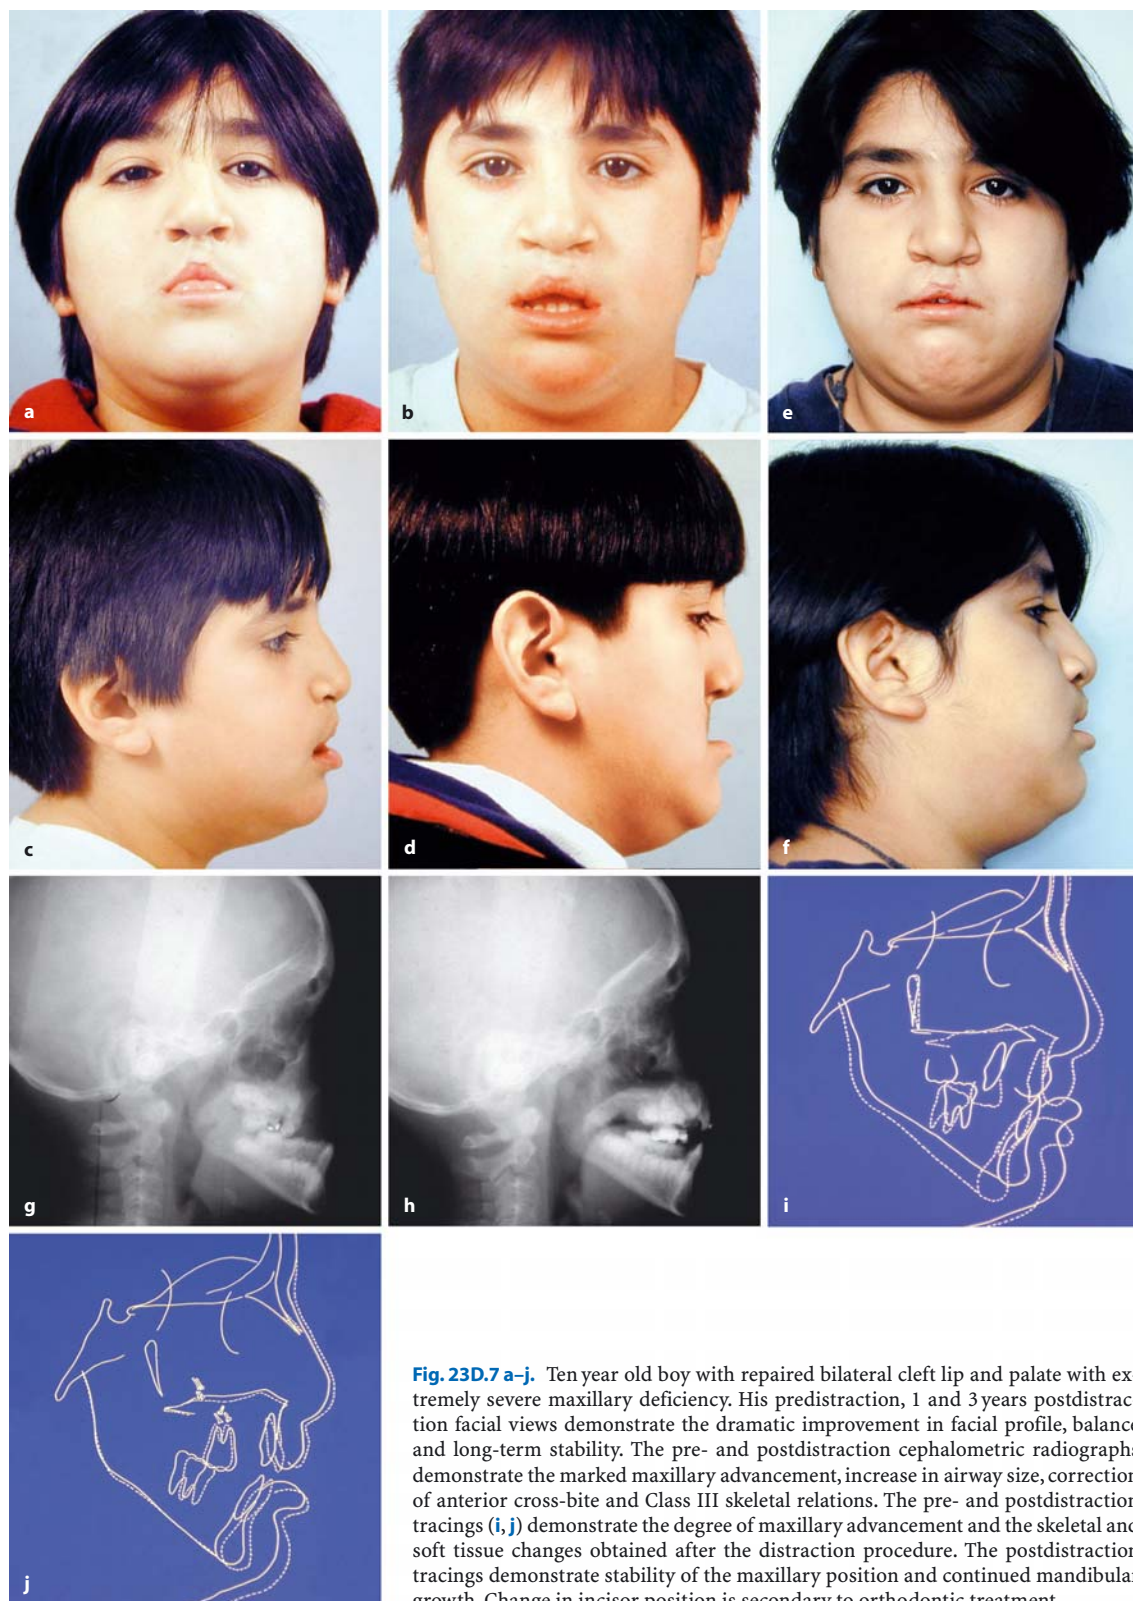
7 a–j. Ten year old boy with repaired bilateral cleft lip and palate with extremely severe maxillary deficiency. His predistriction, 1 and 3 years postdistriction facial views demonstrate the dramatic improvement in facial profile, balance and long-term stability. The pre- and postdistriction cephalometric radiographs demonstrate the marked maxillary advancement, increase in airway size, correction of anterior cross-bite and Class III skeletal relations. The pre- and postdistriction tracings (i, j) demonstrate the degree of maxillary advancement and the skeletal and soft tissue changes obtained after the distraction procedure. The postdistriction tracings demonstrate stability of the maxillary position and continued mandibular growth. Change in incisor position is secondary to orthodontic treatment
